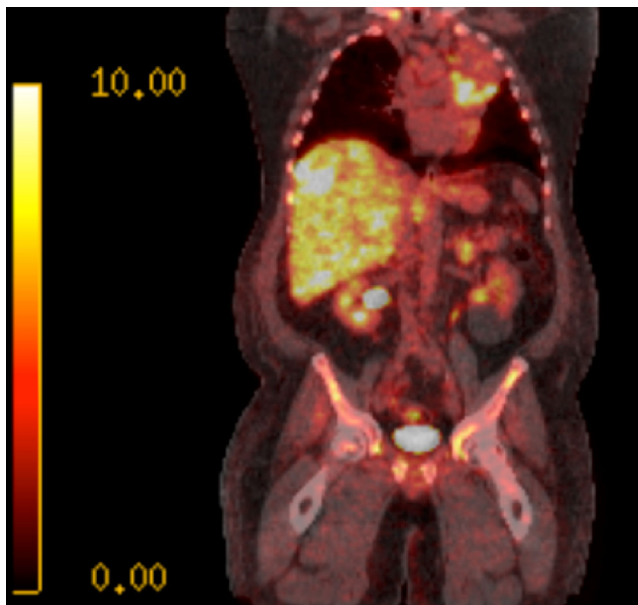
PET-CT of the body. Coronal view reveals a large left upper lobe mass, mediastinal lymphadenopathy, innumerable hepatic and bilateral adrenal lesions, and numerous bony lesions, all of which appear yellow.
